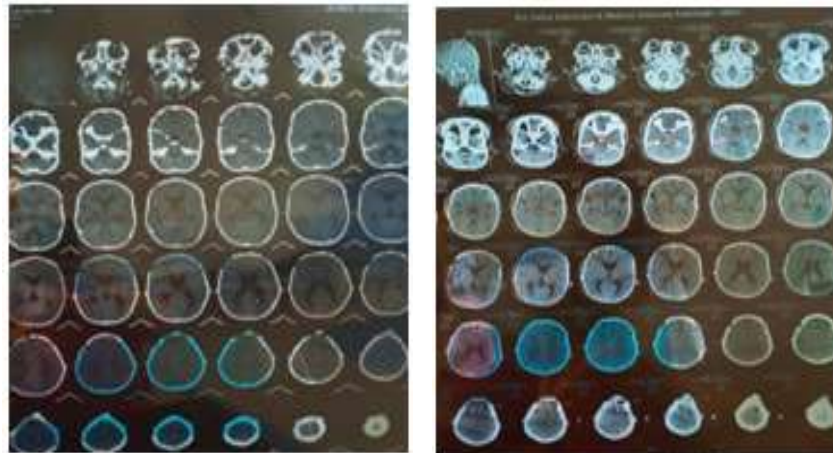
CT Head to rule out premature
